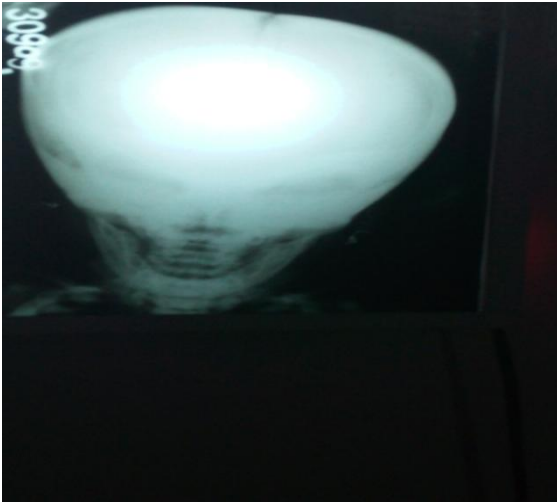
Facial skull radiograph. Note sclerosis of the orbits and sphenoid bones resulting in “Harlequin mask appearance”
